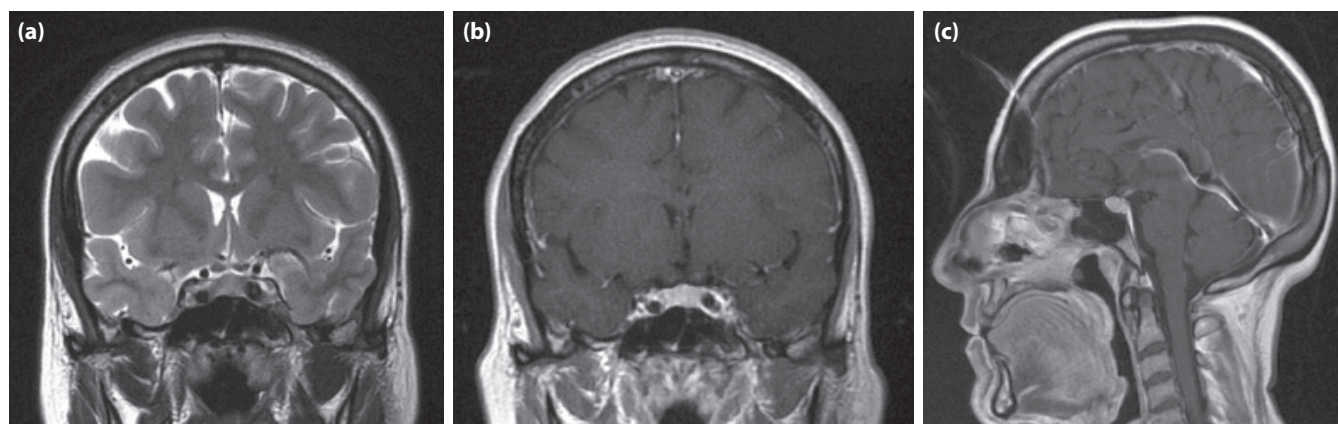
(a, b) A coronal T2W and coronal T1-weighted MR image following the intravenous injection of gadolinium shows caudal displacement of optical chiasm and increases of enhancement and expansion due to hyperaemia at cavernous sinuses and pituitary gland. (c) Contrast-enhanced sagittal T1-weighted MR image shows sagging at the upper brain stem and expansion of the dural venous sinuses.
